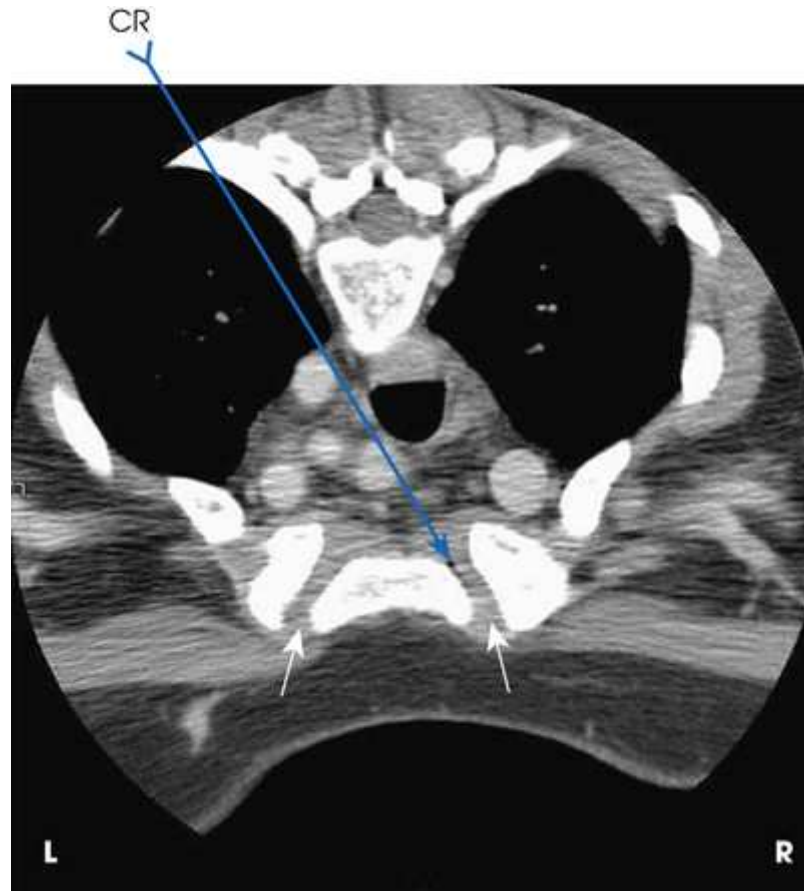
CT axial image with patient prone, showing sternoclavicular joints (*white arrows*) and path of CR. View is from feet looking upward.
